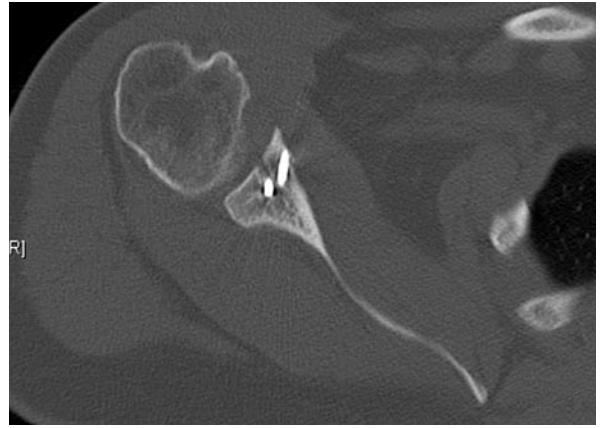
Computed tomography shows placement of bone block and its reproduction of anterior glenoid rim.
